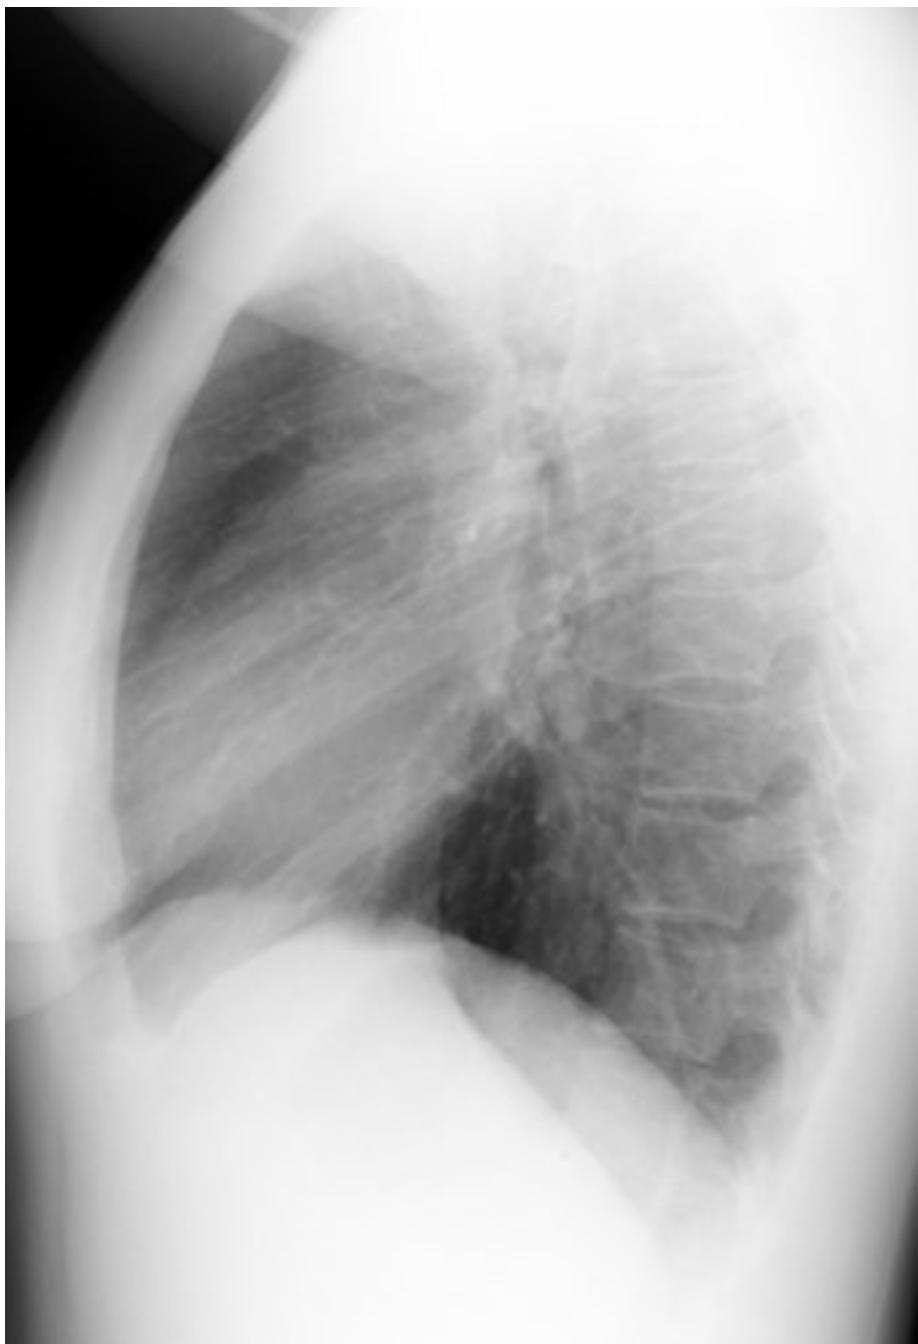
Normal lateral chest radiograph.
